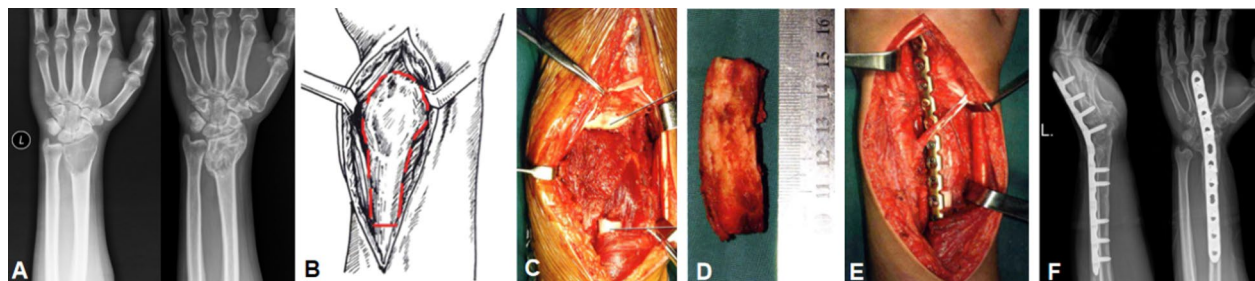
A 48-year-old male with left distal radius recurrent Campanacci III GCTB treated with inadequate curettage as initial treatment. This figure shows procedures for tumor resection and reconstruction. A The distal radial X-ray before and after the denosumab therapy. B-C A dorsal approach was used to expose the tumor location. D-E The structural ICBG was harvested and reconstructed by autografts and a reconstruction plate. F The X-ray showed that the wrist was fixed at 15°-20°dorsal extension
